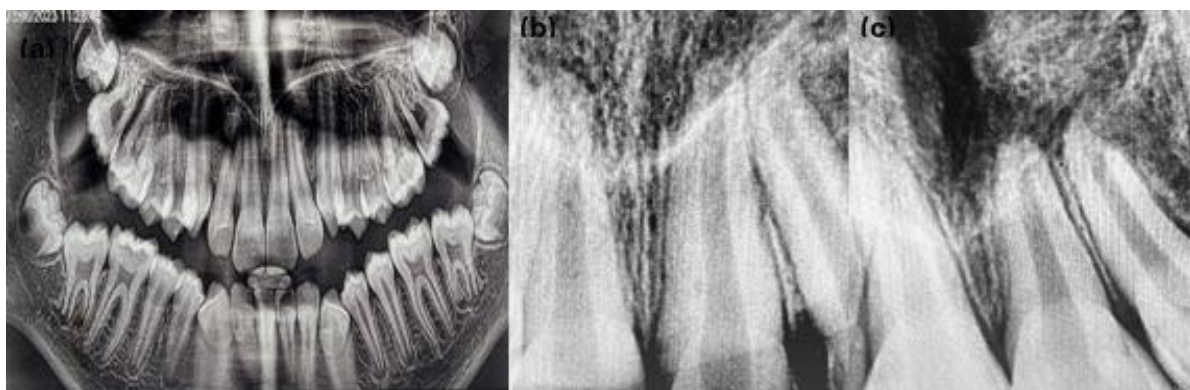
(a) Panoramic radiograph taken two weeks after ; (b, c) Follow-up radiographs at one and two months showing no pathological signs
